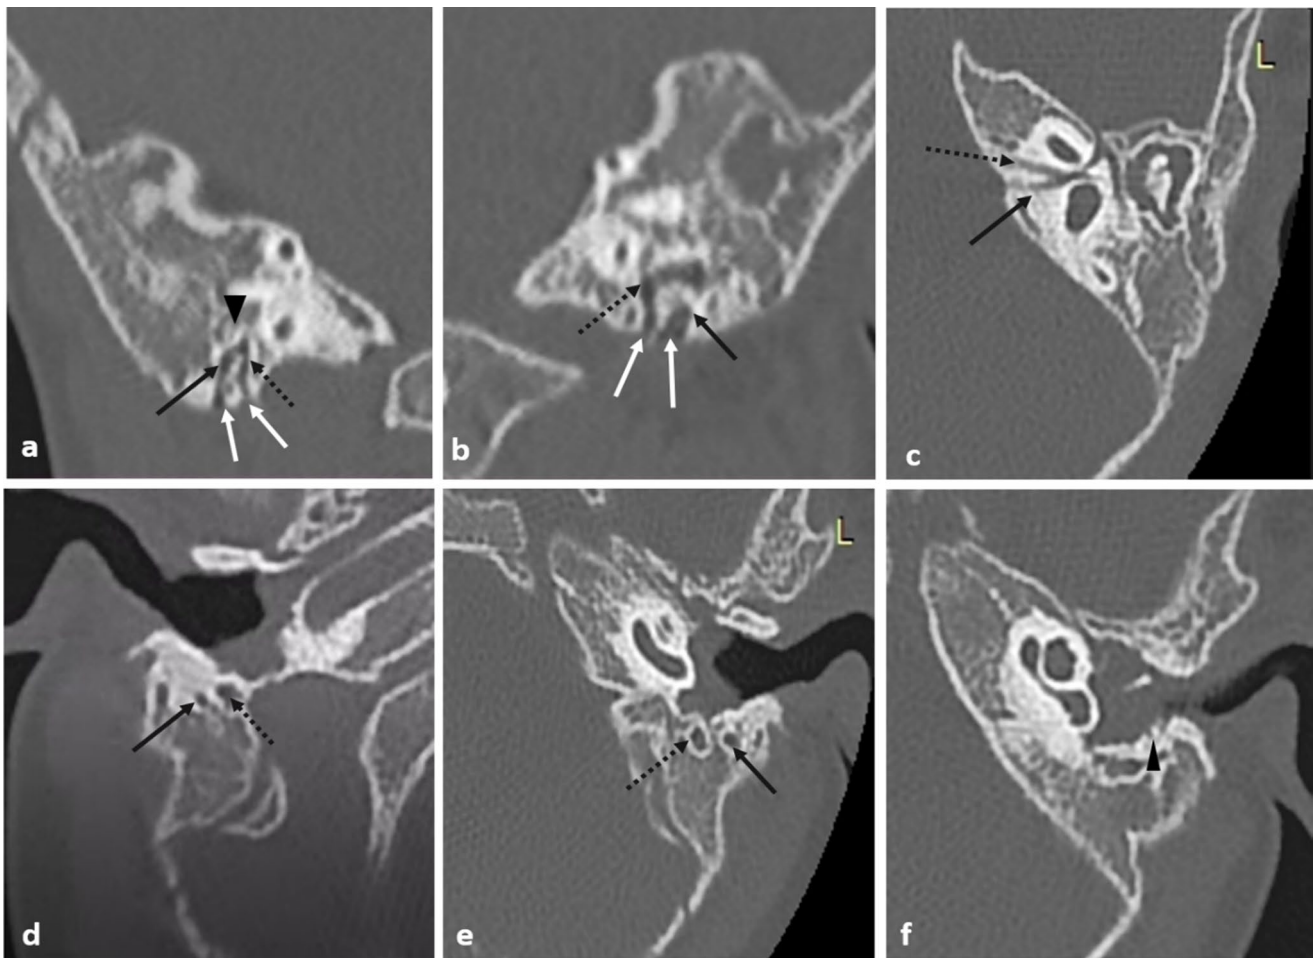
Temporal bone CT scan of patient1: coronal (a, b) and axial (c–f) and slides showing: a–e Bifurcation of the mastoid segment of the right FN (a, d) and the left FN (b–e). We note the presence of an external branch (black arrow) and an internal branch (dashed black
